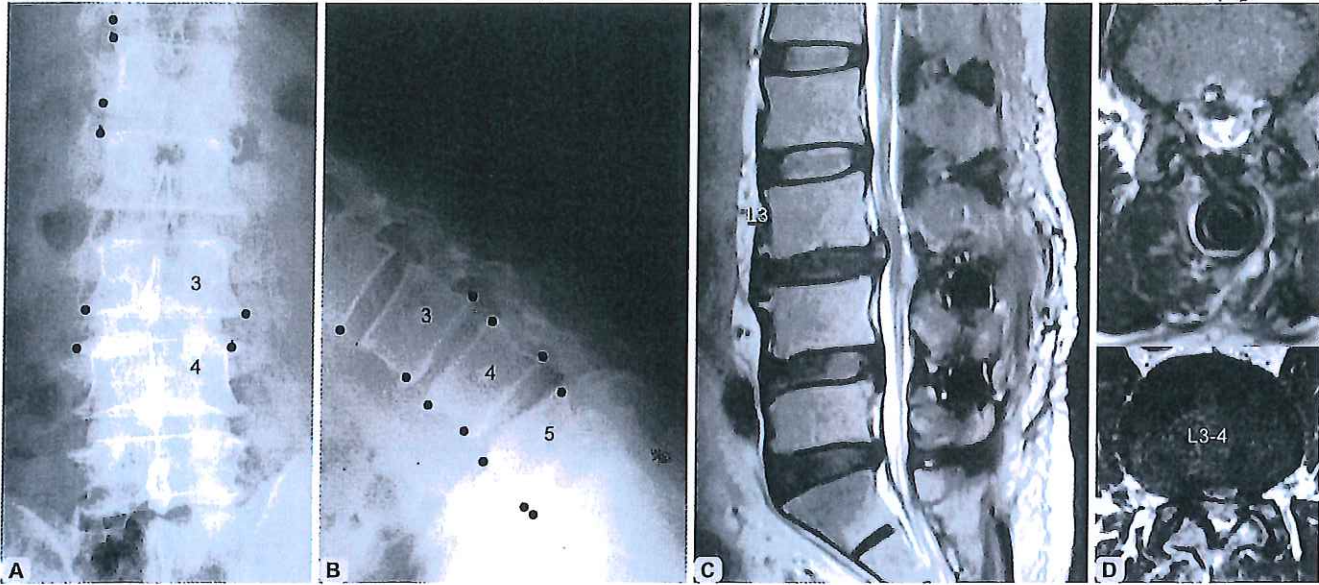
(A and B) Radiographs showing grade I listhesis at L4–5; (C and D) MRI showing a huge bulging of L4–5; (E and F) Decompression and discectomy performed; (G and H) Postoperative MRI showing no complaint
